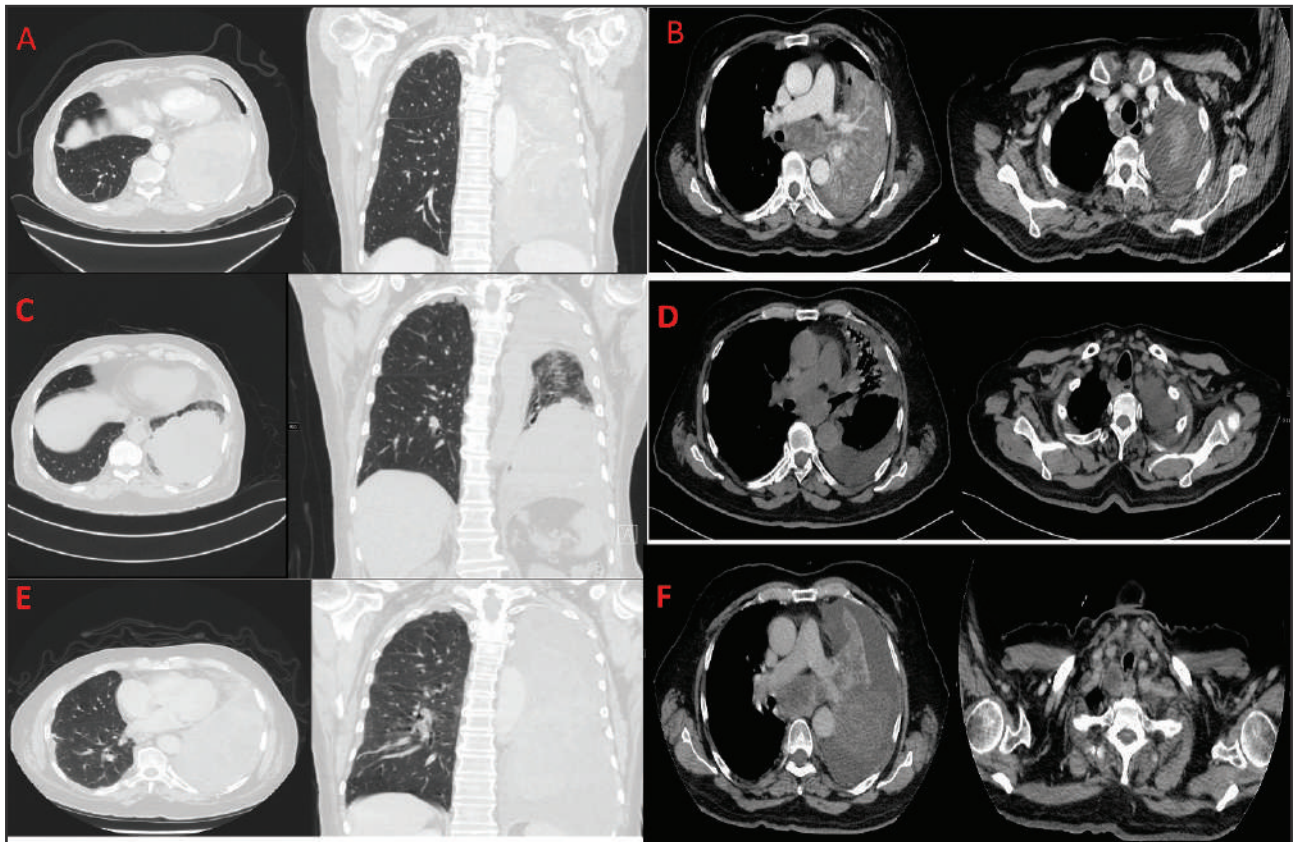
Pre-radiotherapy chest CT scan
